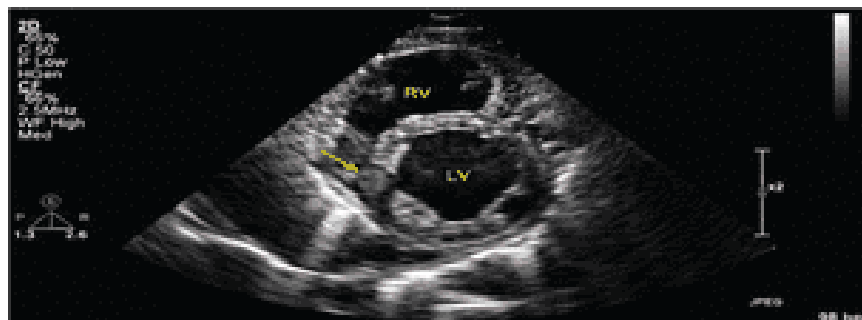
Transthoracic echocardiography (parasternal short-axis view) demonstrating a dilated right ventricle with interventricular septal flattening (D-shaped left ventricle), indicating right ventricular pressure overload.
